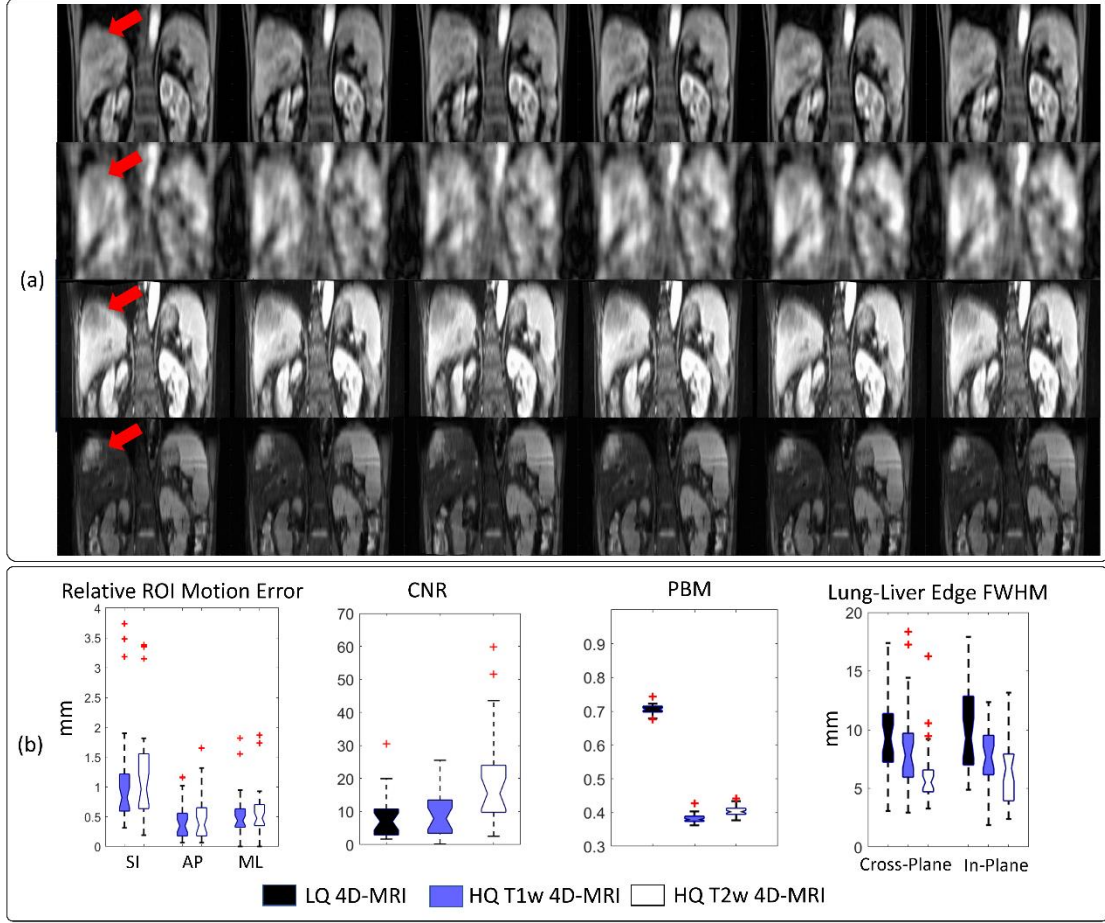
(a) (From top to bottom) The LQ 4D-MR image, downsampled 4D-MR image, HQ T1w 4D-MR image, and HQ T2w 4D-MR image of an example patient in the coronal view. Arrows indicate the tumor in the first frame. The images represent 3D volumes, but only 2D slices are shown for demonstration. (b) The relative ROI motion error ($N = 31$) in HQ Mp 4D-MR images, CNR ($N = 22$), PBM ($N = 31$), and lung–liver edge sharpness ($N = 31$) of different 4D-MR images.
